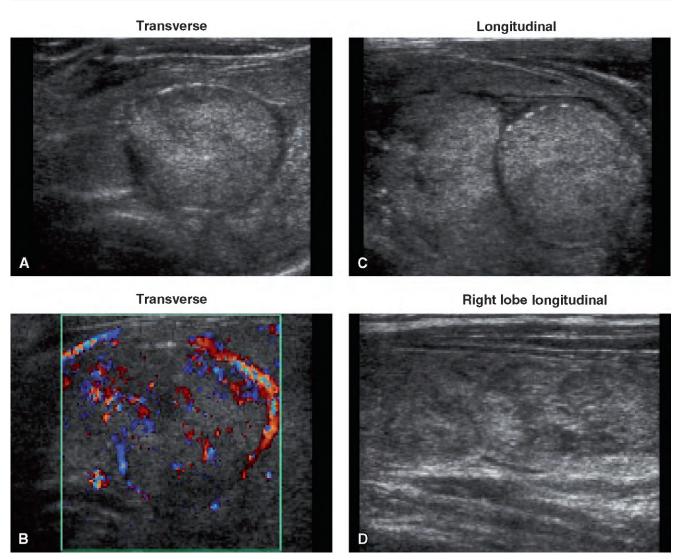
Ultrasound of colloid nodules in the left (A–C) and right (D) lobes. A, Transverse, 12 x 21 mm. B, Color Doppler, transverse. C, Longitudinal, sagittal diameter: 40 mm. D, Right lobe longitudinal.
